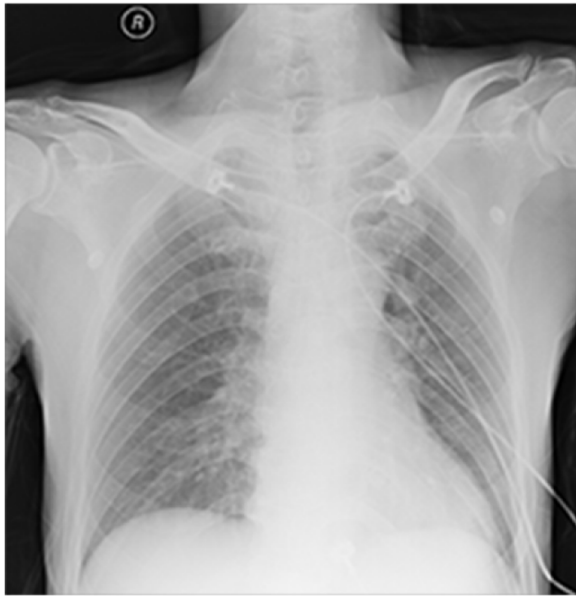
A typical post-operative chest X-ray obtained from a patient with suspected VAE. The X-ray examination was conducted immediately after the surgery. The radiograph shows increased pulmonary markings and local pulmonary edema
